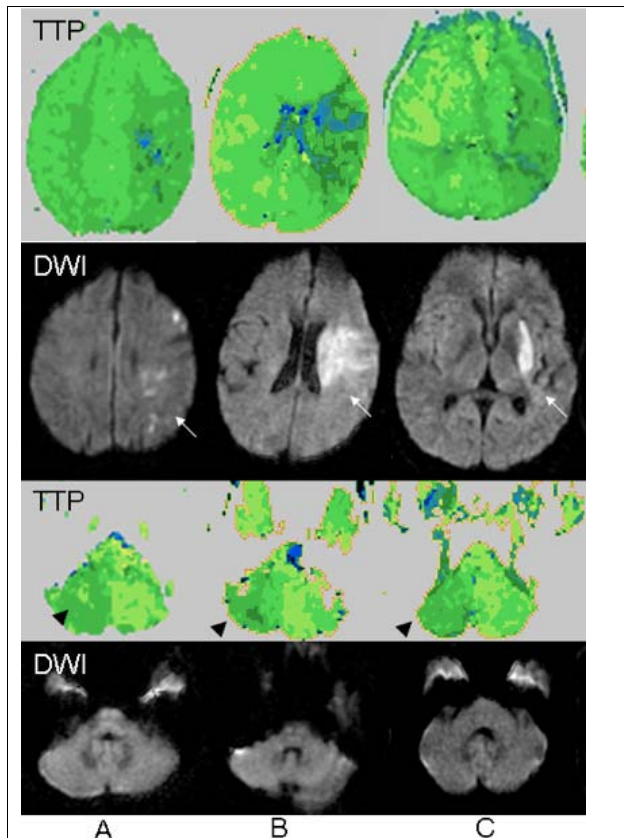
CCH (arrowhead, on TTP maps, row 3) detected in 3 patients with supratentorial infarction (white arrows - top two rows). DWI confirms lack of cerebellar infarction in each case (bottom row).
